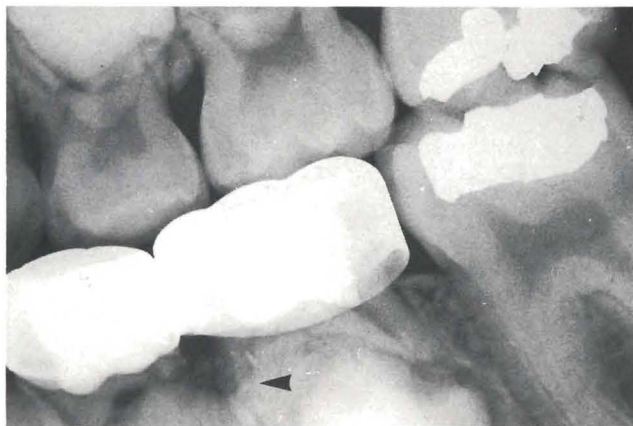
Periapical radiograph with radiopaque mass in the area of the developing second premolar.
